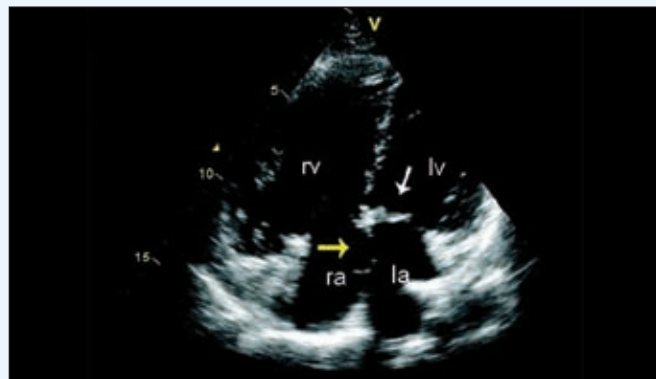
Echocardiogram of a corrected AVSD and pulmonary arterial hypertension in a patient with ALK2 mutation (R307L).
